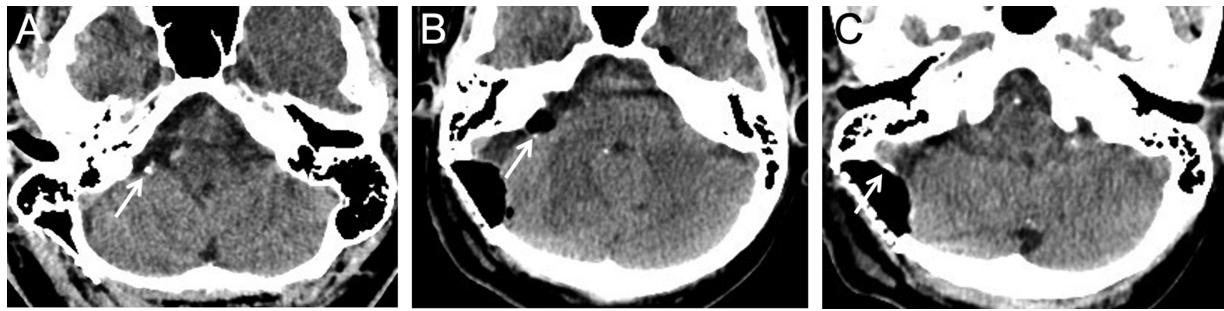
Bone spicules on post-operative head CT examinations after retrosigmoid craniectomy for VS resection. A single bone spicule is noted in (A) (arrow) along the posterior margin of the resection cavity, abutting the right flocculus. CT examination of a separate patient (B and C) demonstrated multiple bone spicules along the posterior resection cavity (B, arrow) and contouring the craniectomy site (C, arrow). CT, computed tomography; VS, vestibular schwannoma.
